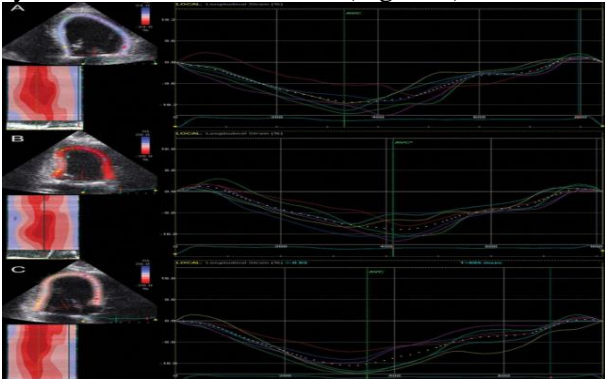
Assessment of LV global and segmental longitudinal strain by 2D speckle-tracking analysis in apical 4 (A), apical 2 (B) and apical 3 (C) chamber views ⁽¹⁴⁾
